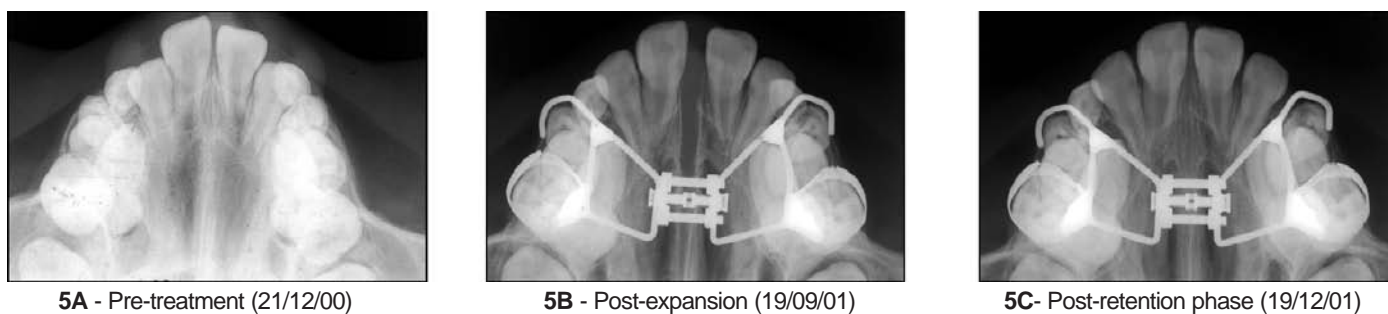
Longitudinal occlusal radiographs of the maxilla showing the behavior of the midpalatal suture: (A) pre-treatment; (B) post-expansion (end of active phase); and (C) post-retention phase with the expander.
